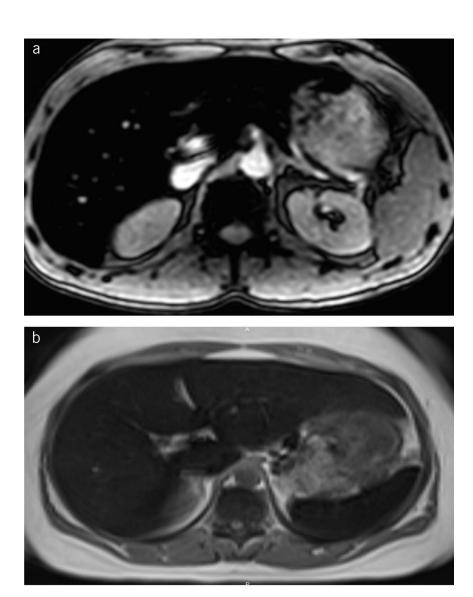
MRI of *HFE* iron overload and secondary iron overload. (a) Iron deposition in the liver from type 1 hereditary hemochromatosis; (b) iron deposition in the liver and spleen on the MRI, consistent with secondary iron overload.
